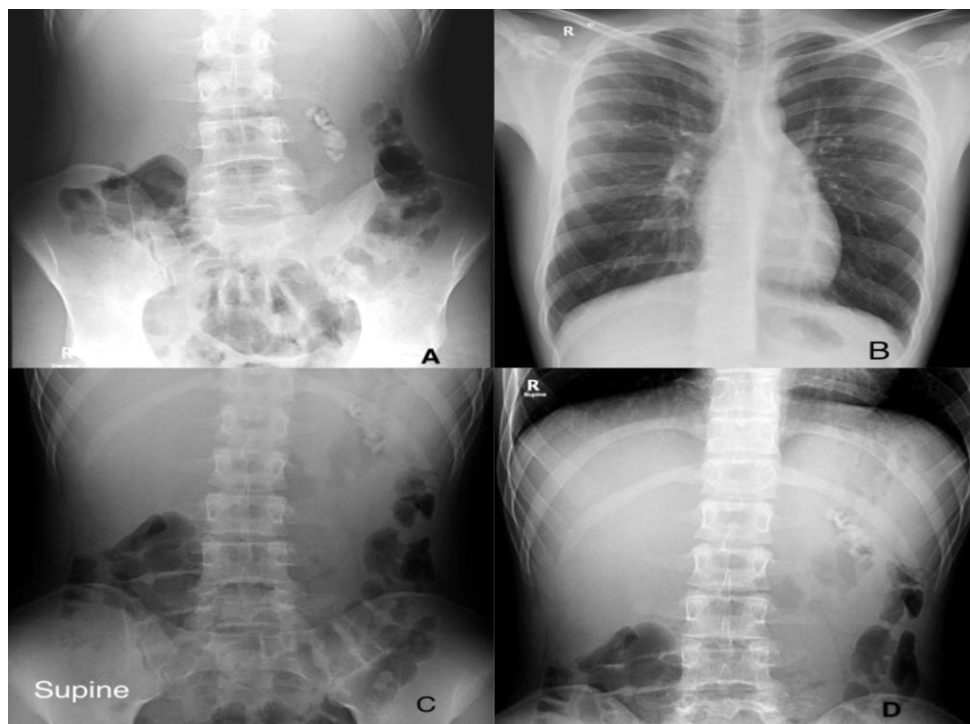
(A) Upright abdomen X-ray showing radiopaque material, (B) AP chest X-ray, (C and D) Supine abdomen X-ray showing the radiopaque material
